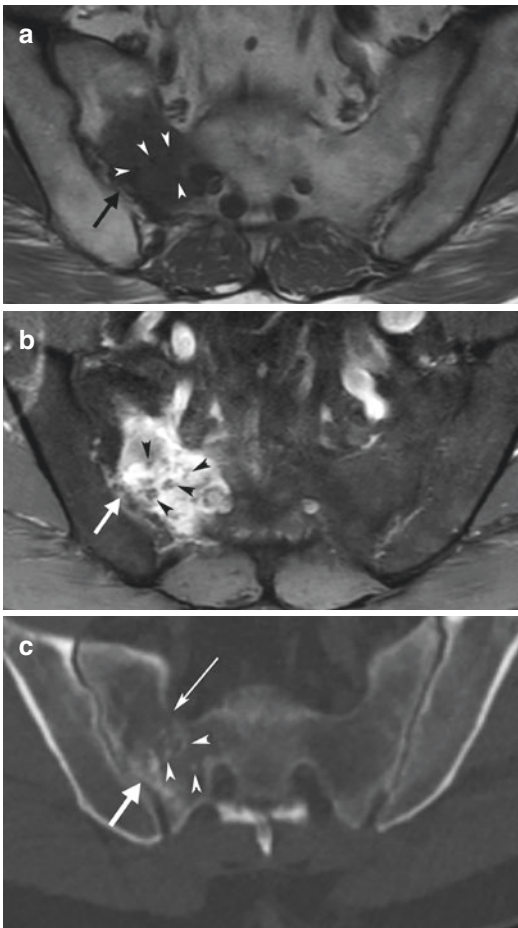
A 60-year-old man with sacral chondrosarcoma. Axial T1 (a) and T2 (b) images of the sacrum demonstrate a heterogeneous marrow-replacing lesion (arrows) in the right S1 sacral ala, with multiple punctate hypointense foci (arrowheads). (c) Corresponding unenhanced CT confirms mineralized chondroid matrix (arrowheads) within the mass (large arrow) and focal anterior cortical destruction associated with the mass (thin arrow)
